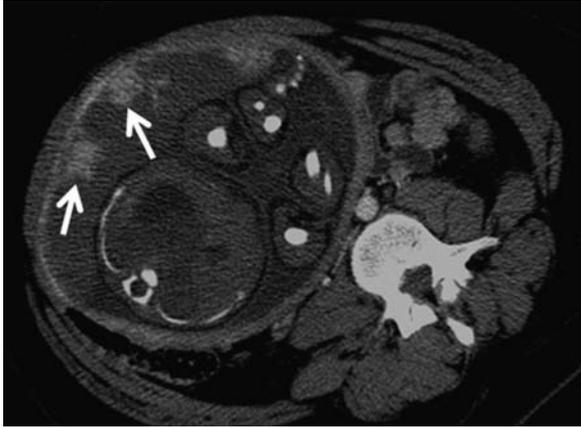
Computed tomographic appearance of a placental abruption. A 32-year-old woman at 30-week gestational age, who was involved in high velocity motor vehicle collision, underwent contrast-enhanced computed tomography for trauma evaluation. Axial computed tomographic image obtained through the abdomen shows a largely devascularized placenta with few remaining areas of enhancement (arrows), representing substantial posttraumatic placental abruption. The patient also had traumatic brain injury, multiple facial fractures, pelvic and rib fractures, and a liver laceration (not shown). An emergent cesarean section was performed to rescue the fetus.
